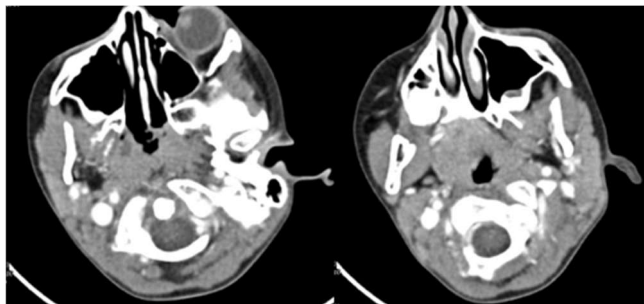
CT-scan axial view shows atlanto-axial dislocation. Fielding Hawkin I. (own source)
